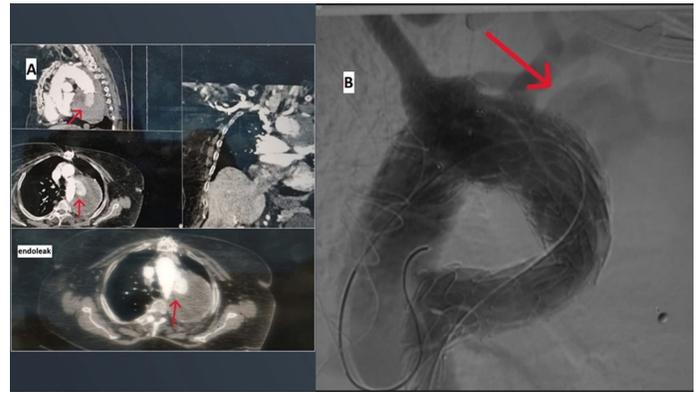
Red arrows pointing at Endoleak A. in CT cuts. B. in angiography
